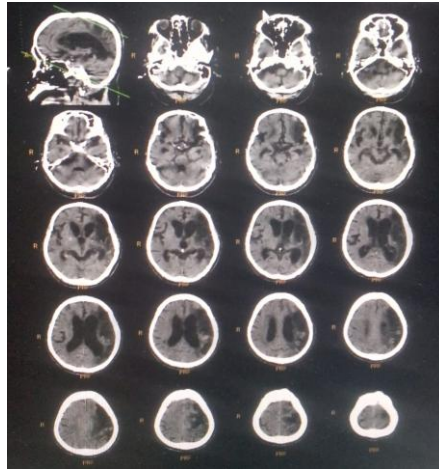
CT-Scan Examination Results
